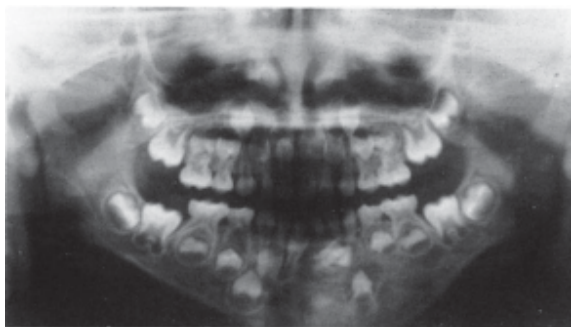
Panoramic radiograph showing complete obliteration of the cystic cavity by normal bone, eleven months post-operatively.
